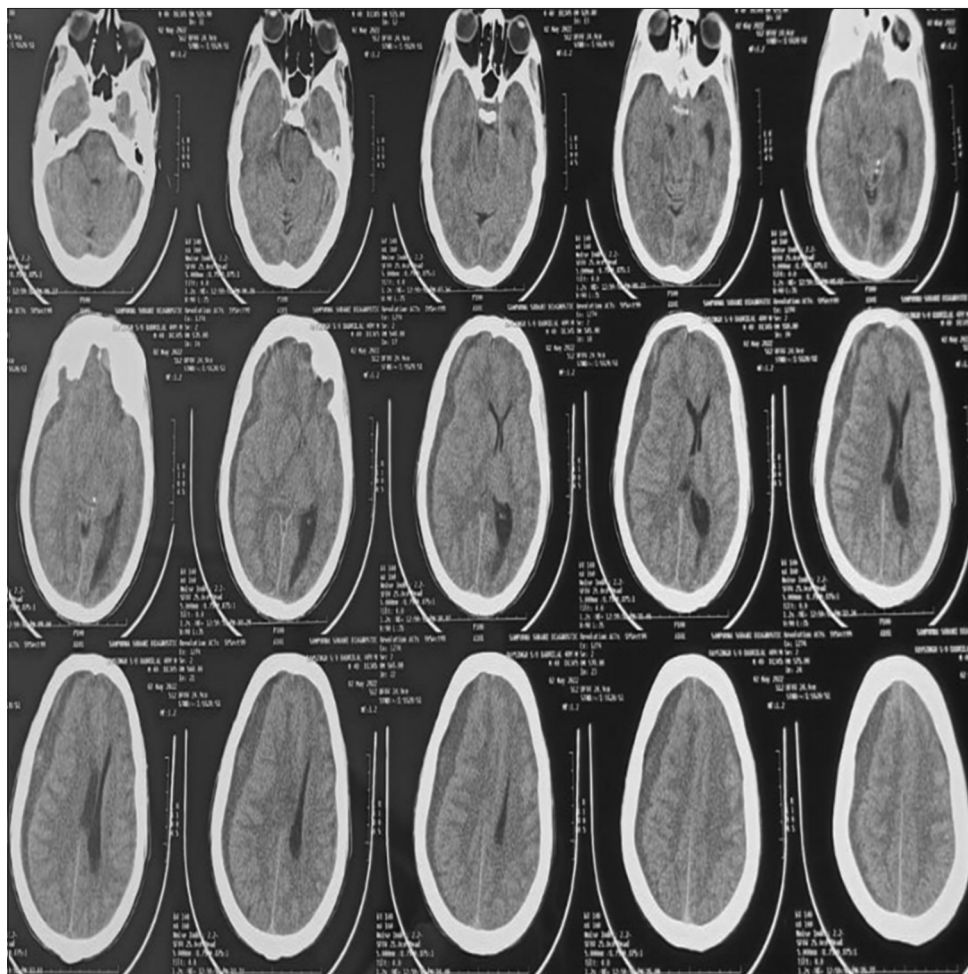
preoperative non-contrast computed tomography head suggestive of right fronto-temporo-parietal chronic subdural hematoma
